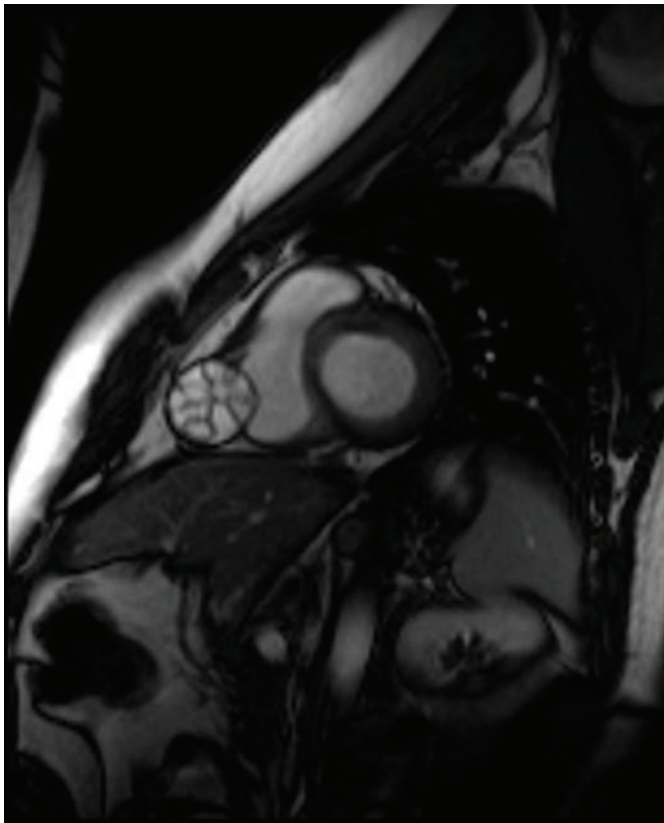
Magnetic resonance imaging of a transverse section of a cardiac hydatid cyst.
